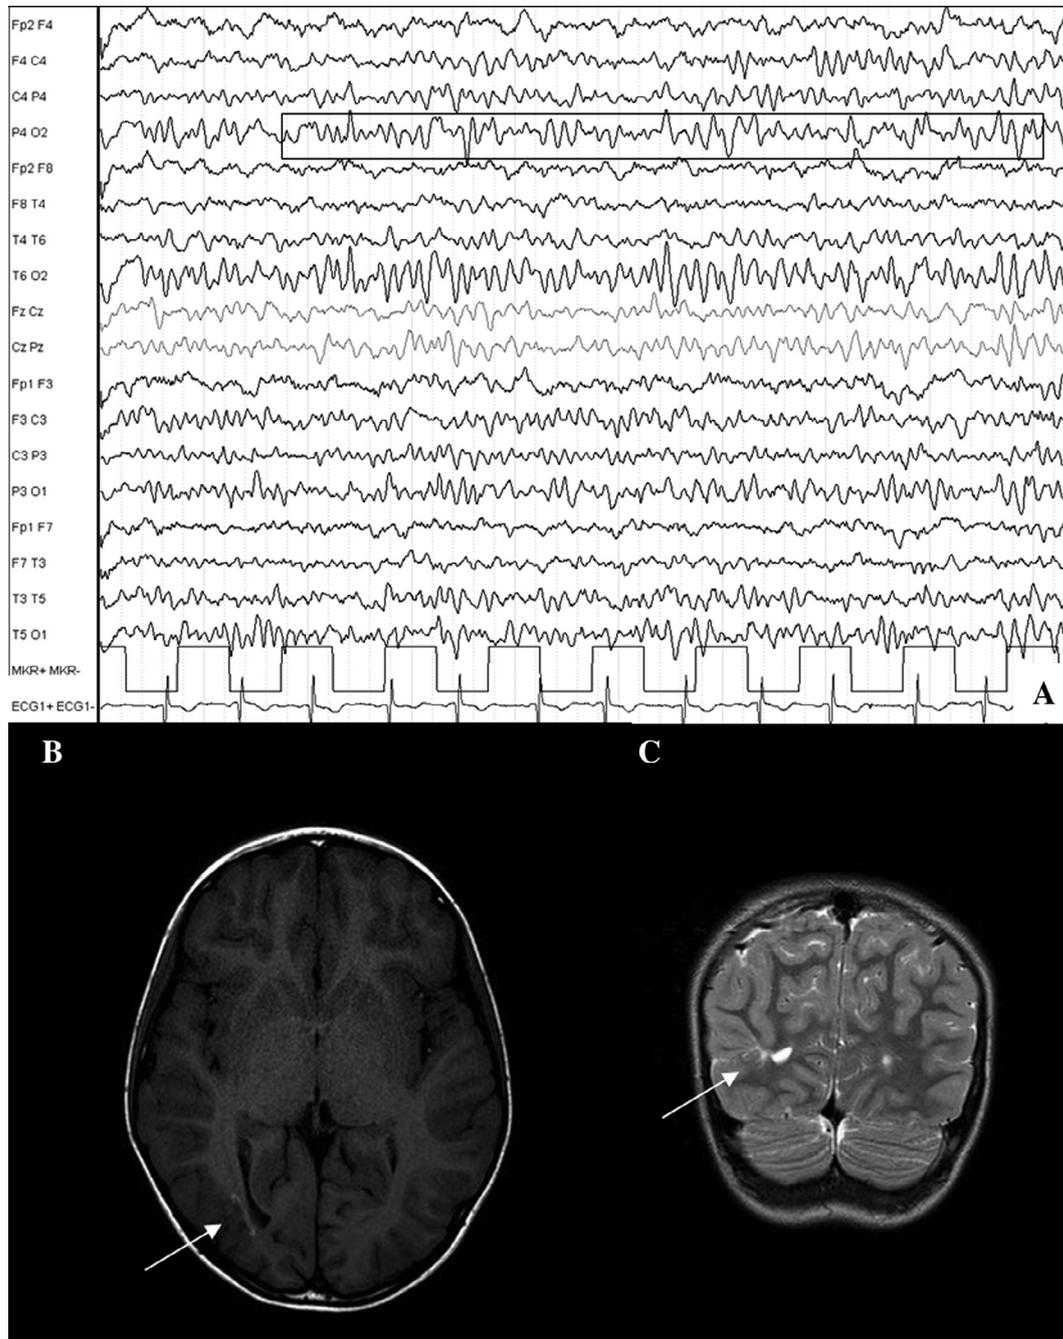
(A) EEG recording during wakefulness, showing an asymmetry of the background activity with theta-delta rhythms in the right posterior areas (bandpass filter: 1, 6–70 Hz; notch 50 Hz; sens: 100  $\mu$ V/cm). (B) (axial T1-weighted image) and (C) (coronal T2-weighted image): MRI images showing a small infarct in the right occipito-parietal lobe.
